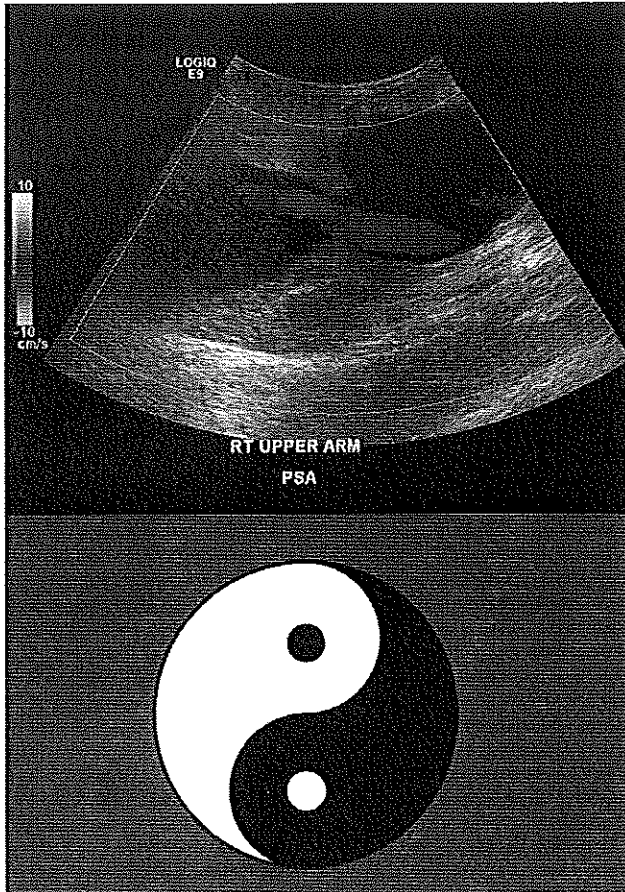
Classic sonographic Yin-yang sign of pseudoaneurysms.
